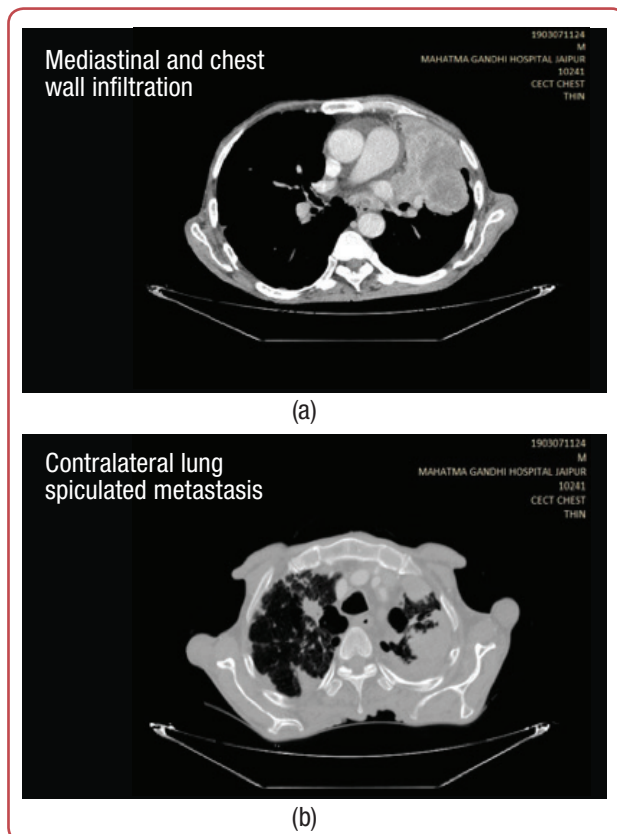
(a) Contrast enhanced computed tomography (CECT) chest axial scan showing chest wall and mediastinal invasion by mass. (b) CECT chest axial view lung window showing contralateral lung metastasis as spiculated nodular margins.
